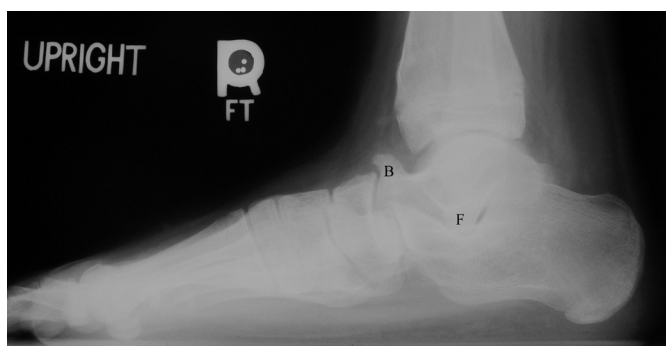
Clinical example. Figure 3a. (left) Lateral radiograph of accessory anterolateral talar facet (F – accessory facet, B – dorsal talar beak). Figure 3b. (right) CT scan (F – accessory facet, B – dorsal talar beak).
